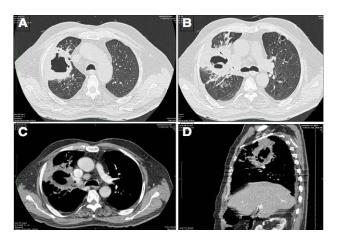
CT scan chest showing a thick-walled cavity with air-fluid level in the right upper lobe.
